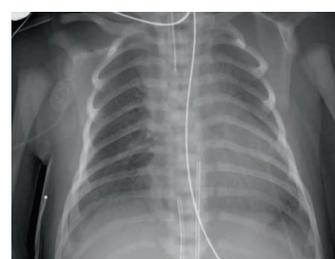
X-ray following setting change
